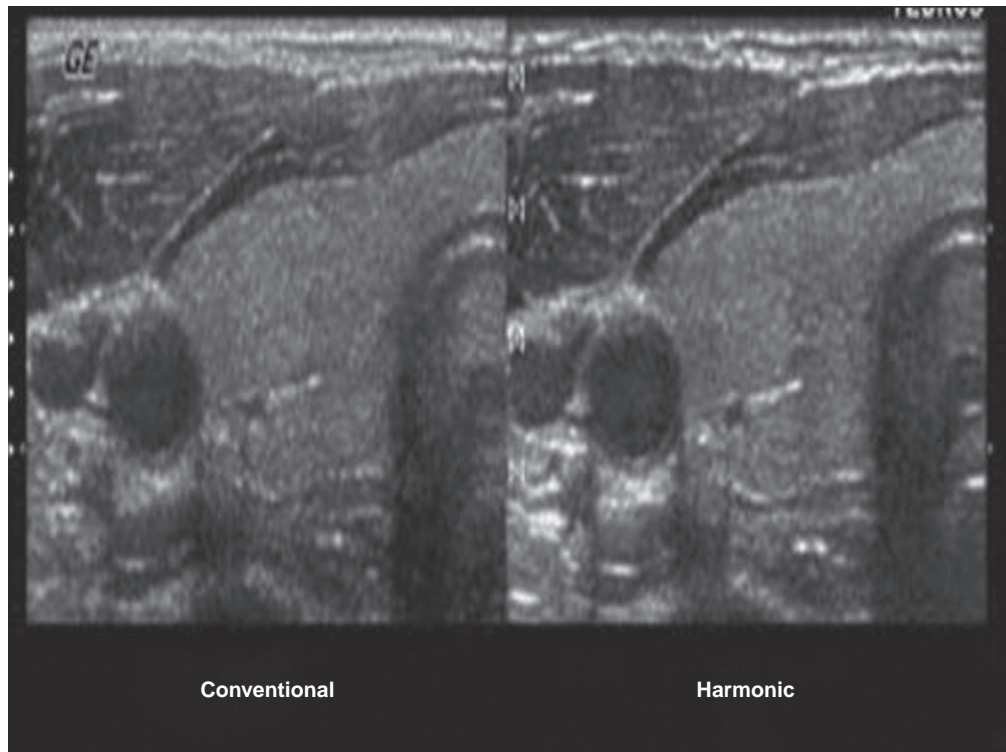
Conventional versus ultrasound harmonic imaging. (From Tranquart F, Grener N, Eder V, Pourcelot L, et al: Clinical use of US tissue harmonic imaging. *US Med Biol* 1999;25:889-894.)
